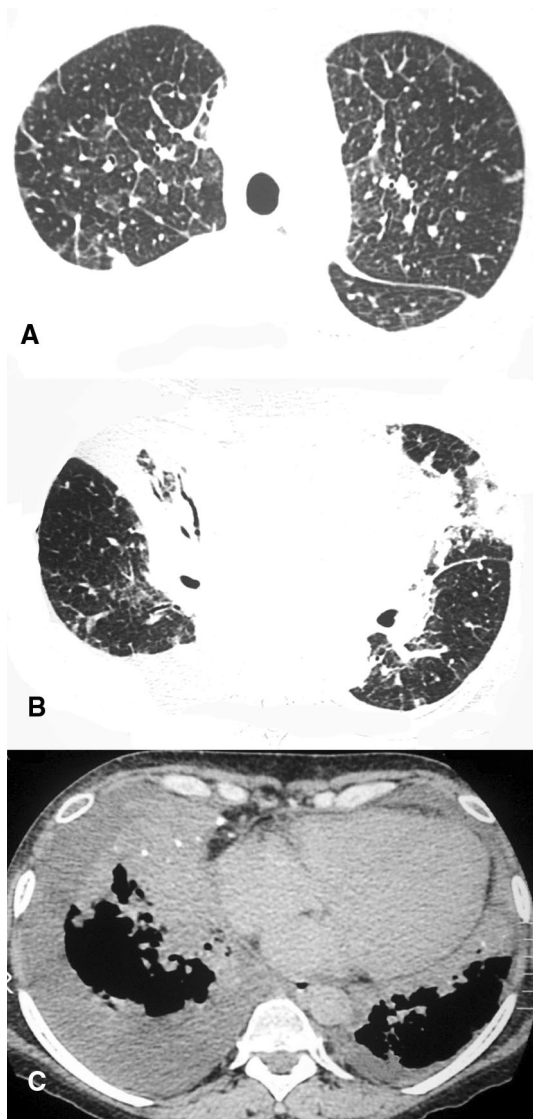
A 50-year-old woman who reported dyspnea for 4 months. Axial CT image with the lung window setting at the level of the upper lung (a) shows diffuse, smooth interlobular septal thickening with nodulation. Axial CT images with lung (b) and mediastinal (c) window settings at the level of the lower lung show parenchymal consolidations with air bronchogram and small punctate foci of calcification. Bilateral pleural effusion, more extensive on the right side, is also present
